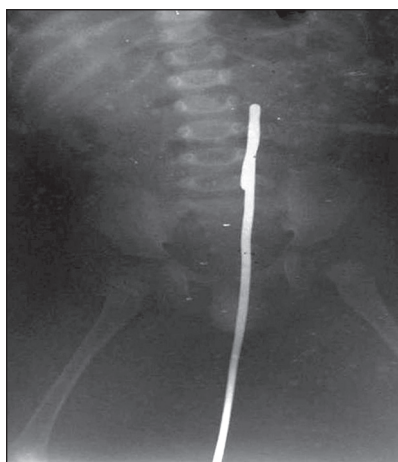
Plain X-ray abdomen erect anteroposterior view showing a long steel bar with bent end inside the peritoneal cavity with no free gas
